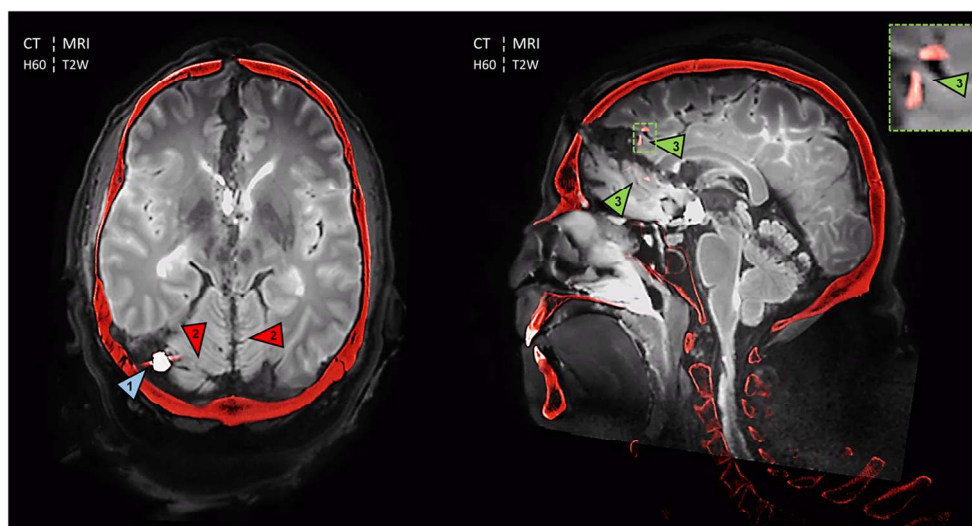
The fusion of CT and MRI (CT bone (H60): highlighted in red; MRI: 3D T2-weighted (T2W)) aligned to the bullet path demonstrates the diagnostic strength of both imaging modalities in cases of penetrating gunshot wounds. By windowing into a higher range, the soft tissue visually disappeared on CT, while osseous lesions, bone fragments and the projectile, pellets or bullet fragments were still clearly visible. The now invisible soft tissue from CT was replaced by the detailed soft tissue from MRI by automated image fusion. While postmortem CT depicts the inwardly beveled cranial bone fracture at the entrance, locates the lodged
